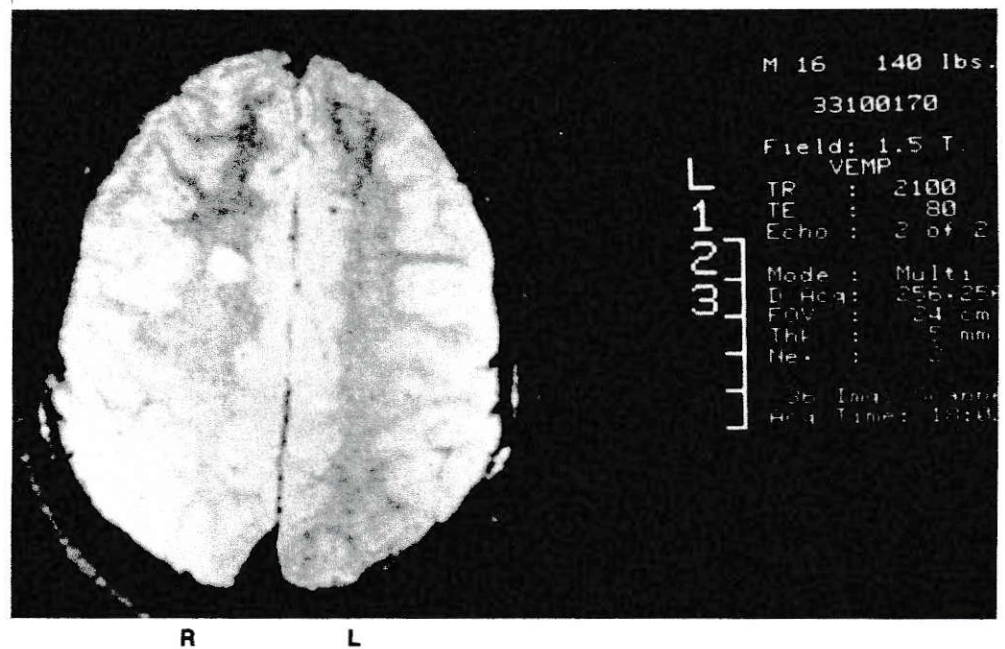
Post-traumatic right frontal hematoma of chronic nature. EEG was normal. MRI was interpreted as metastatic tumor. (Patient had a malignant melanoma of the right thigh.)
